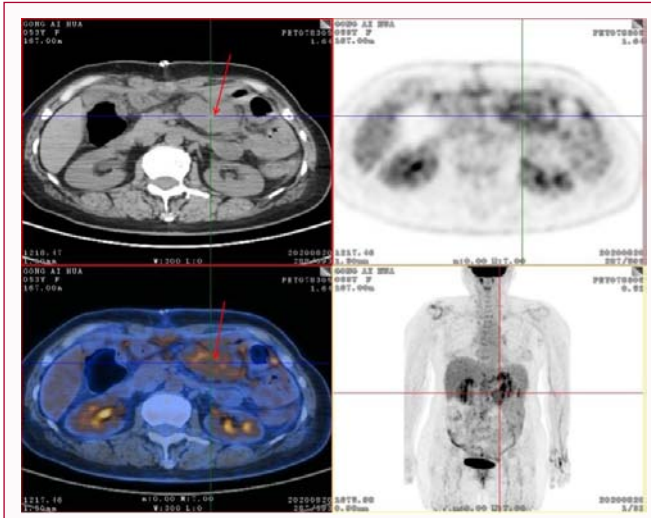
PET-CT showed a 6.2x4.2 cm solid mass with high metabolic expression in the left upper quadrant (SUVmax=6.2).
